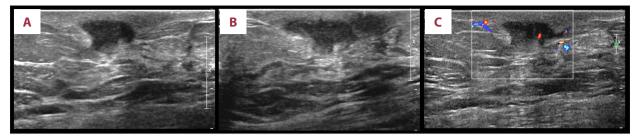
(A) Transverse and (B) longitudinal gray-scale sonograms show an irregular indistinct heterogeneous hypoechoic mass in the left subareolar area. Note the posterior enhancement deep to the mass. (C) Color Doppler sonogram shows a degree of increased vascularity within the mass and adjacent tissue.
